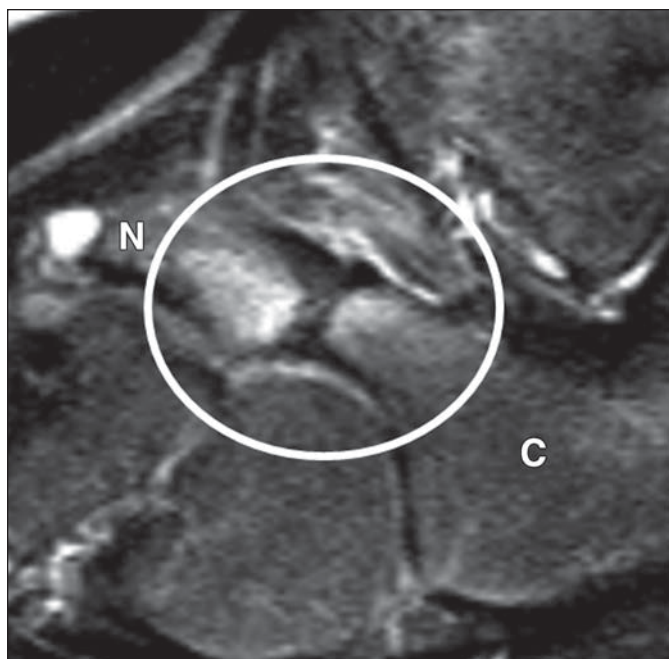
9-year-old male athlete with right subtalar foot pain. Sagittal fat-suppressed fast spin-echo T2-weighted images of foot show nonosseous calcaneonavicular coalition with bone marrow edema pattern (circle) on either side of joint, similar to MRI appearance of FOPE (focal periphyseal edema) zone. N = navicular bone, C = calcaneus.
